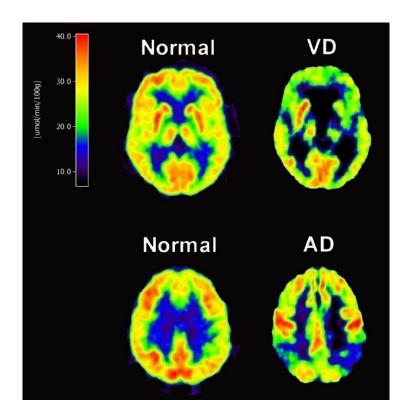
Brain hypometabolism in dementia patients showed by 18F-FDG PET. AD, Alzheimer's patients; VD, vascular dementia. Reprint from Jacobset al., 2005 (26).
